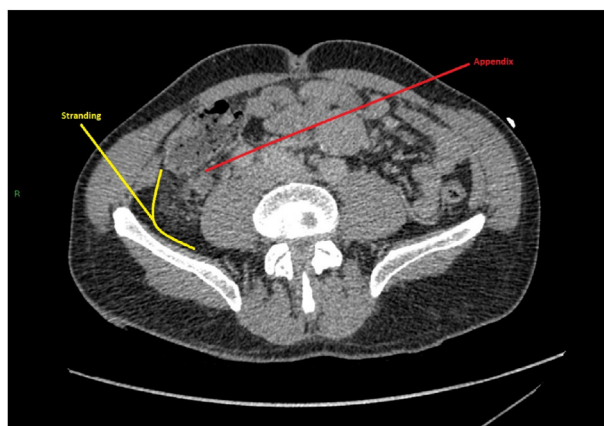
Abdominal CT scan axial view showing the inflamed retrocecal appendix.
